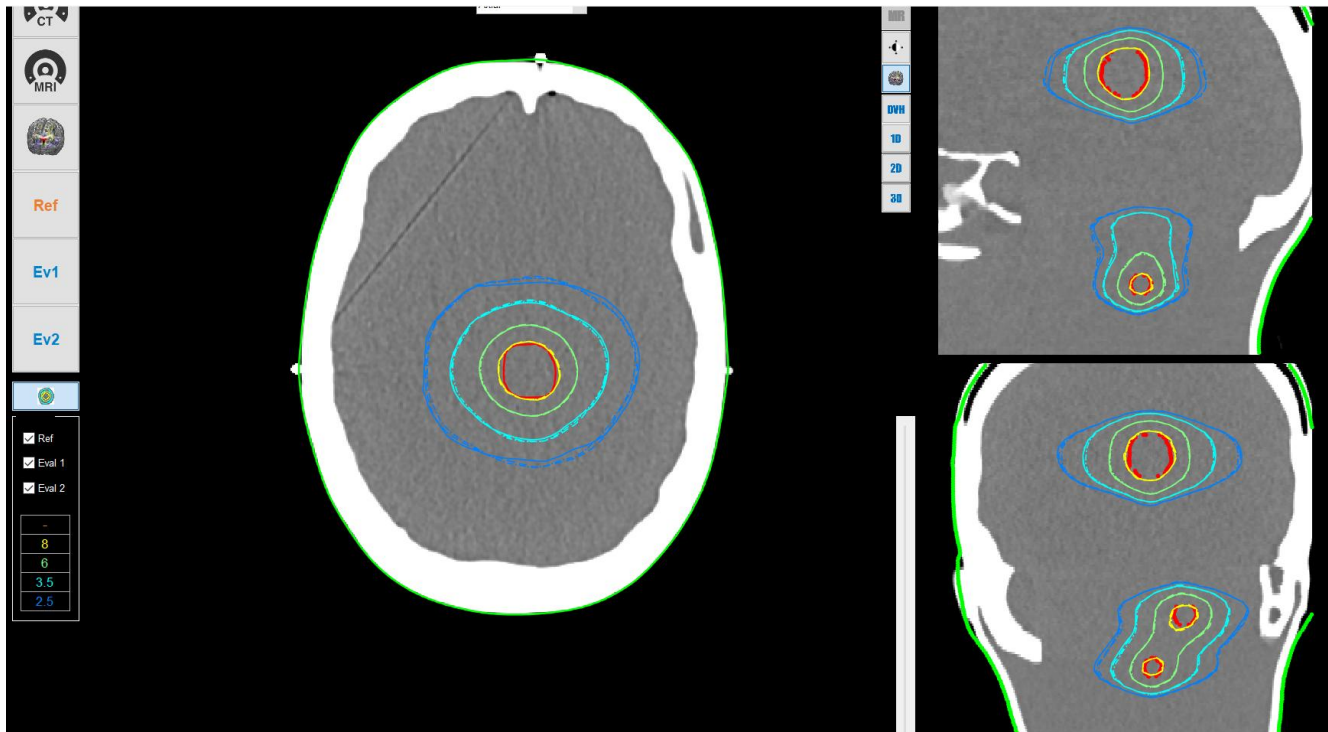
Multi-planar CT views with REF, Eval1 and Eval2 isodose overlays. The axial, sagittal and coronal panels show closely co-localized high- and intermediate-dose isolines.
